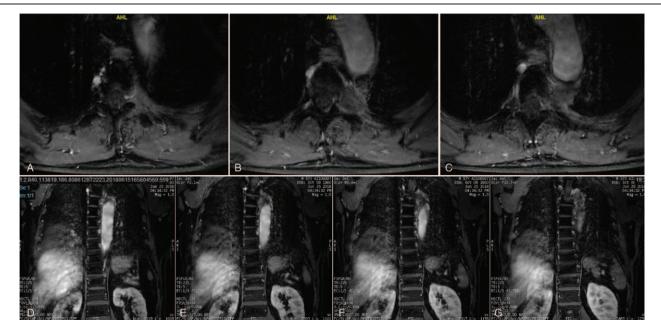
(A–G) Preoperative coronal and transverse MRI images revealing spinal cord compression secondary to the epidural component of the T4 mass, with increased metastatic marrow infiltration of the left T4 vetebral body, which presented as a solid tumor. Tumor infiltrated through the T4 vetebral body into the left pedicle and posterior elements causing significant compression of the nerve root. MRI = magnetic resonance imaging.
